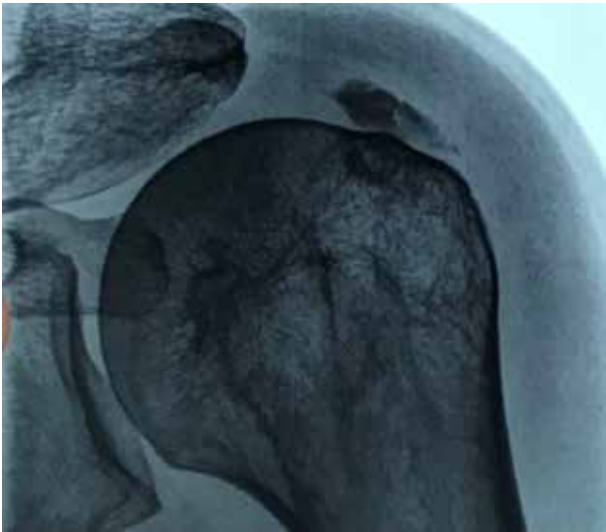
Shoulder plain x-ray showing calcification of the distal end of supraspinatus tendon.
